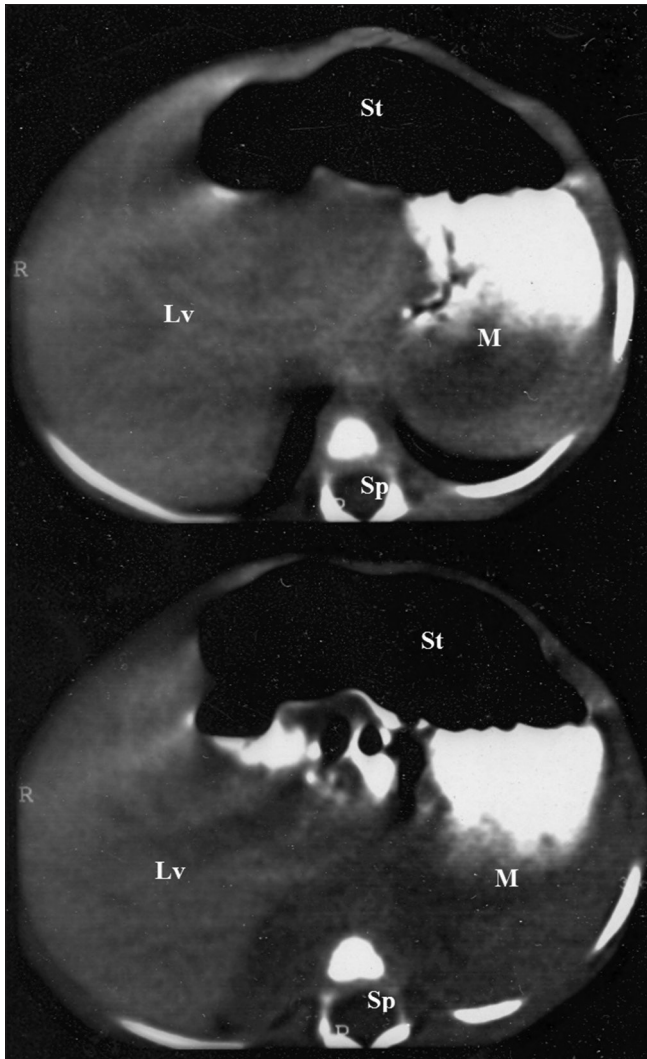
Neonatal abdominal CT with oral contrast: The abdominal CT with oral contrast shows a filling defect of 10 to 20 HU within the stomach (St: Stomach, Lv: Liver, M: Mass, Sp: Spine)
